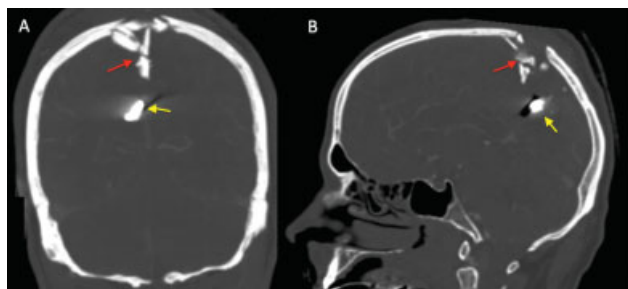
Cranial computed tomography (CCT) with coronal (A) and sagittal (B) cuts, bone window: impression fracture with intracranial bone fragments (*red arrow*) and metallic foreign object (*yellow arrow*).
